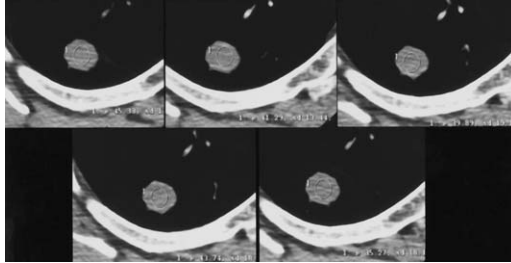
CT nodule enhancement study of a nodule in the posterior segment of the right upper lobe. The top left image is the precontrast image. The other four images were obtained at 1-minute intervals following the injection of intravenous contrast. There was no significant enhancement of the nodule indicating that this nodule is most likely benign. There has been no significant change in the nodule on follow-up examinations.
